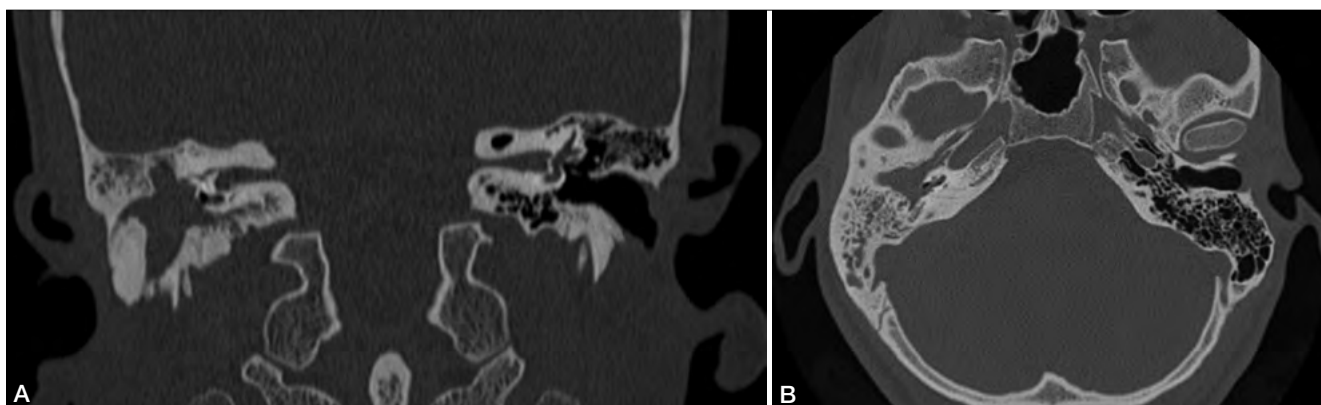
CT scan with bone window; A) coronal view: a large bony mass obstructs the right external auditory canal. This latter and the middle ear are occupied by material with a soft tissue density. The floor of the external auditory canal is eroded as well as the promontorium, with a cochlear fistula confirmed by the presence of air bubbles into the cochlear lumen. B) axial view: the cochlear fistula is best visualised on axial scans.
